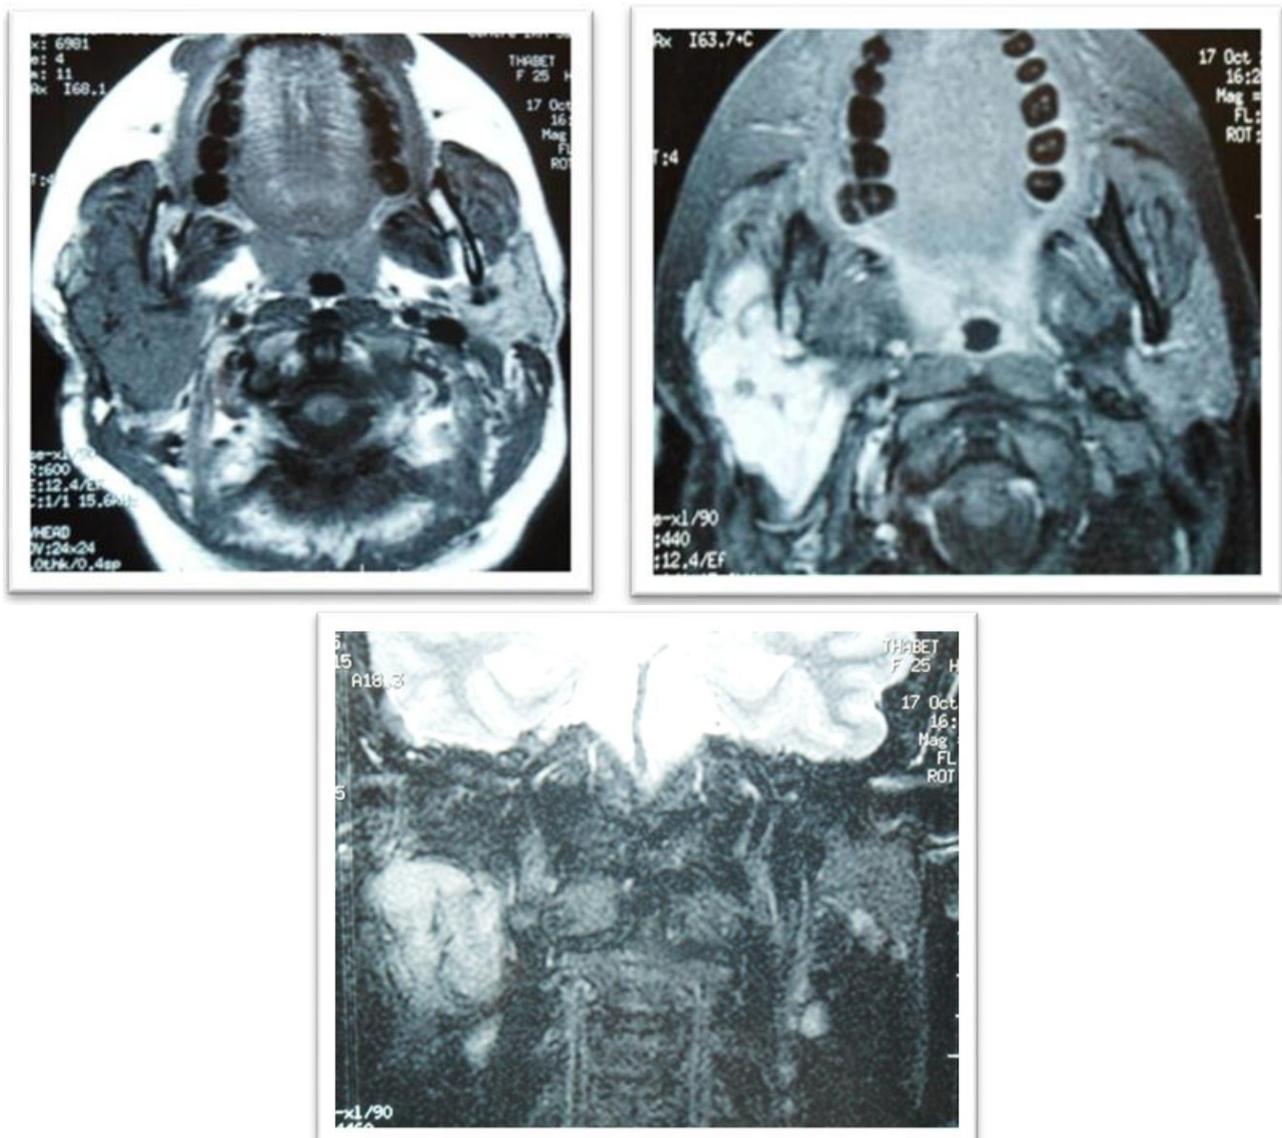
MRI in axial and coronal section showing the left parotid tissue formation in hypoT1 and enhanced after injection of PDC.
